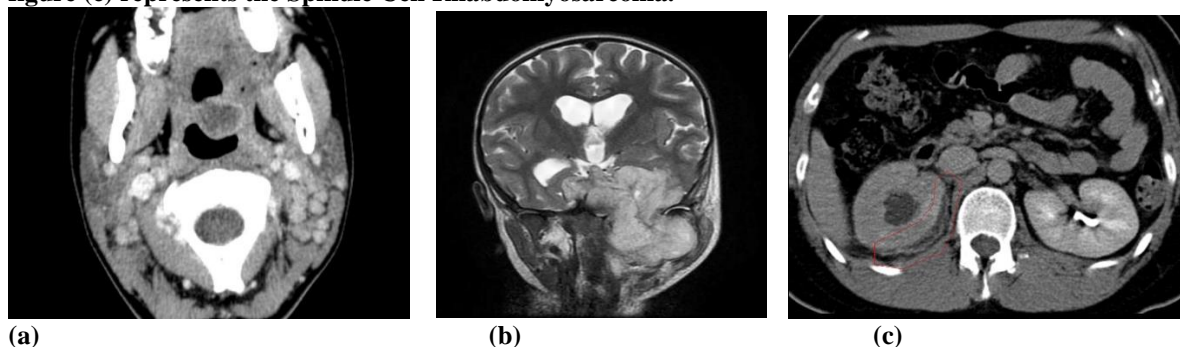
Figure (a) represent the CT image of rhabdomyosarcoma, figure (b) represents the MRI image of rhabdomyosarcoma, figure (c) represents the PET/CT image of rhabdomyosarcoma.
